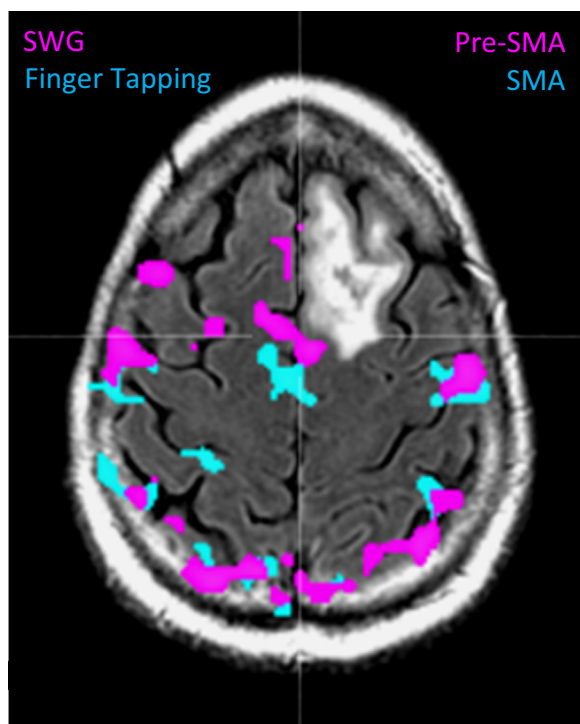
There are no anatomical landmarks to reliably localize the pre-SMA and SMA, yet localization of these can determine the order of tumor border dissections. Axial FLAIR image shows proximity relationships of the pre-SMA and SMA proper to the posterior medial border of a tumor, indicating risk of surgically-induced mutism. Intraoperative functional testing was also planned to preserve language networks along the lateral border of the tumor (not shown). Surgically-induced deficits of the pre-SMA will recover in a matter of weeks, but would eliminate the possibility of testing lateral language networks where deficits can be lasting. Thus, the lateral tumor margins were resected first to preserve permanent language, followed by medial tumor margins. FLAIR, fluid-attenuated inversion recovery. (Color version of figure is available online.)
